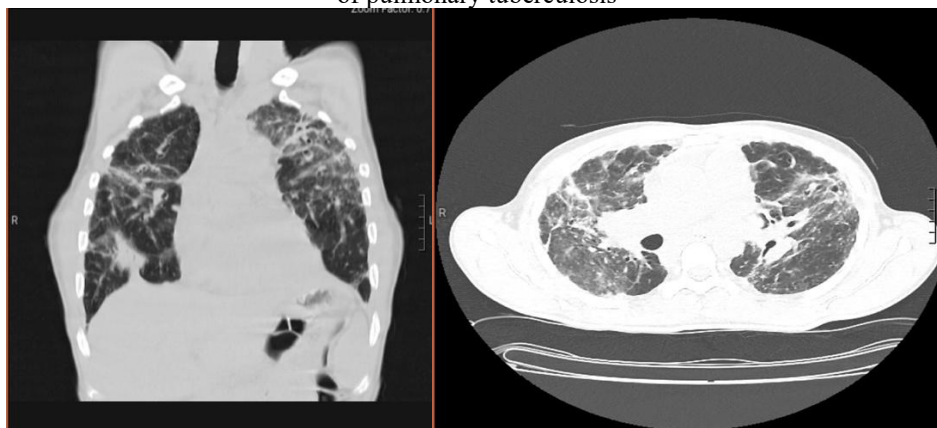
Coronal and axial HRCT chest scans showing diffuse interstitial changes, perihilar consolidative changes and calcified peri-bronchial nodes.
